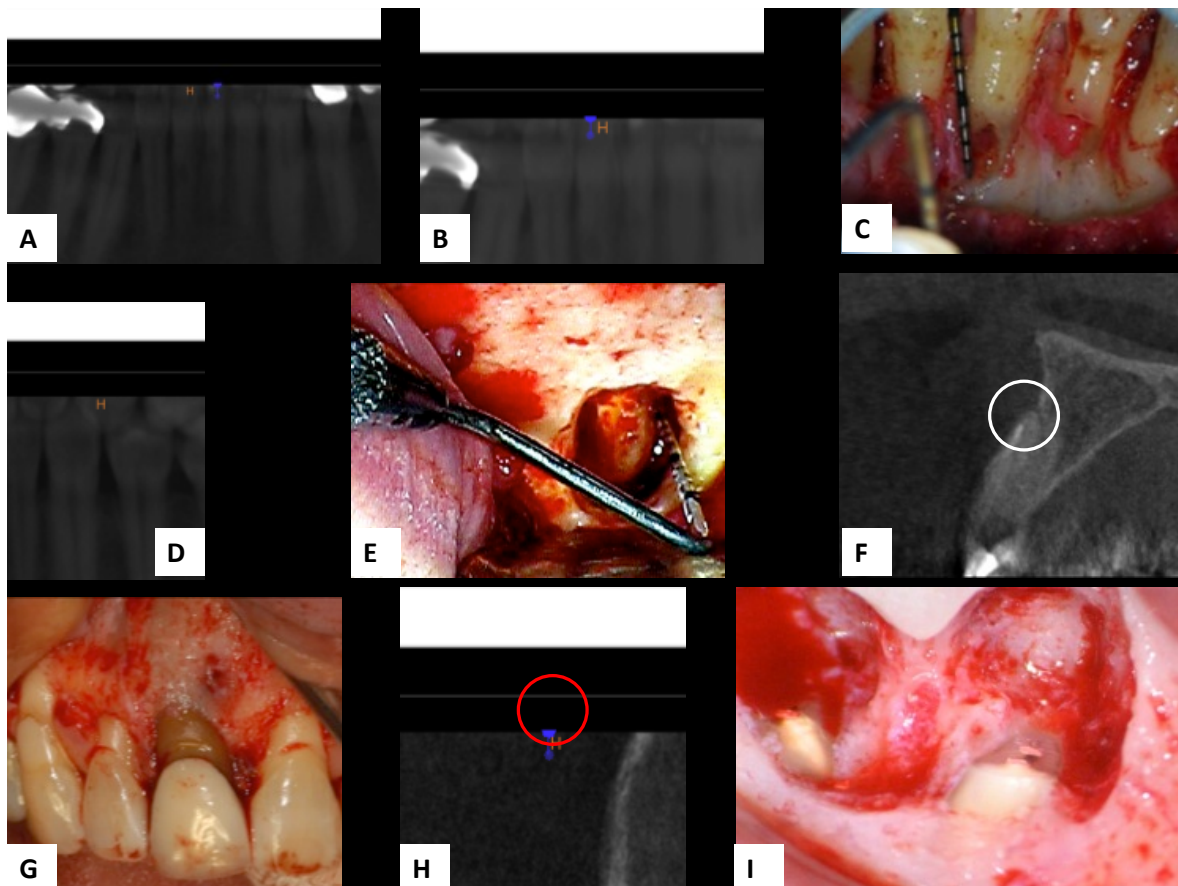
(A) CBCT image displaying a measured distance between the apical margin of a resorptive lesion and the incisal extent of the lingual cortical plate of #24. The software measurement tool established a distance of 3.5mm. (B) Tooth #25 of the same patient measuring inciso-apical distance of resorptive lesion. (C) Clinically, the resorptive defect on #24 was even with bone; therefore, evaluators had underestimated the bone by 3.5mm. On tooth #25, Length of resorptive defect measured on CBCT nearly equals the measured distance. (D-E) CBCT measurement averaged 1.6mm, whereas actual thickness of bone was 2.5mm (F-G) CBCT image and clinical photos incorrectly interpreted as buccal plate perforation of #8 (H-I) CBCT image incorrectly interpreted as sinus perforation. In actuality, thin layer of bone existed.
